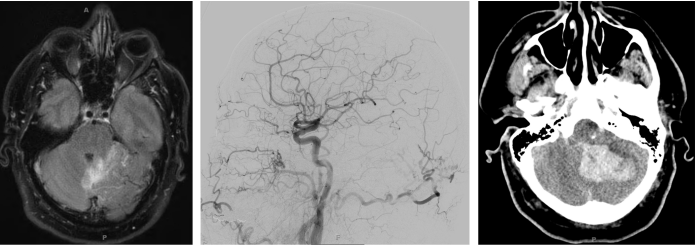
Imaging obtained from a patient who presented with headaches (aCVD) and went on to hemorrhage shortly after presentation. Left: FLAIR MRI obtained at time of presentation showing large area of signal abnormality in the left cerebellar hemisphere. Middle: Angiogram obtained at time of presentation demonstrating a left cerebellar Borden type 3 dural arteriovenous fistula. Right: CT scan obtained four days after diagnosis and two days prior to scheduled treatment showing a large intracranial hemorrhage originating from the dAVF.
